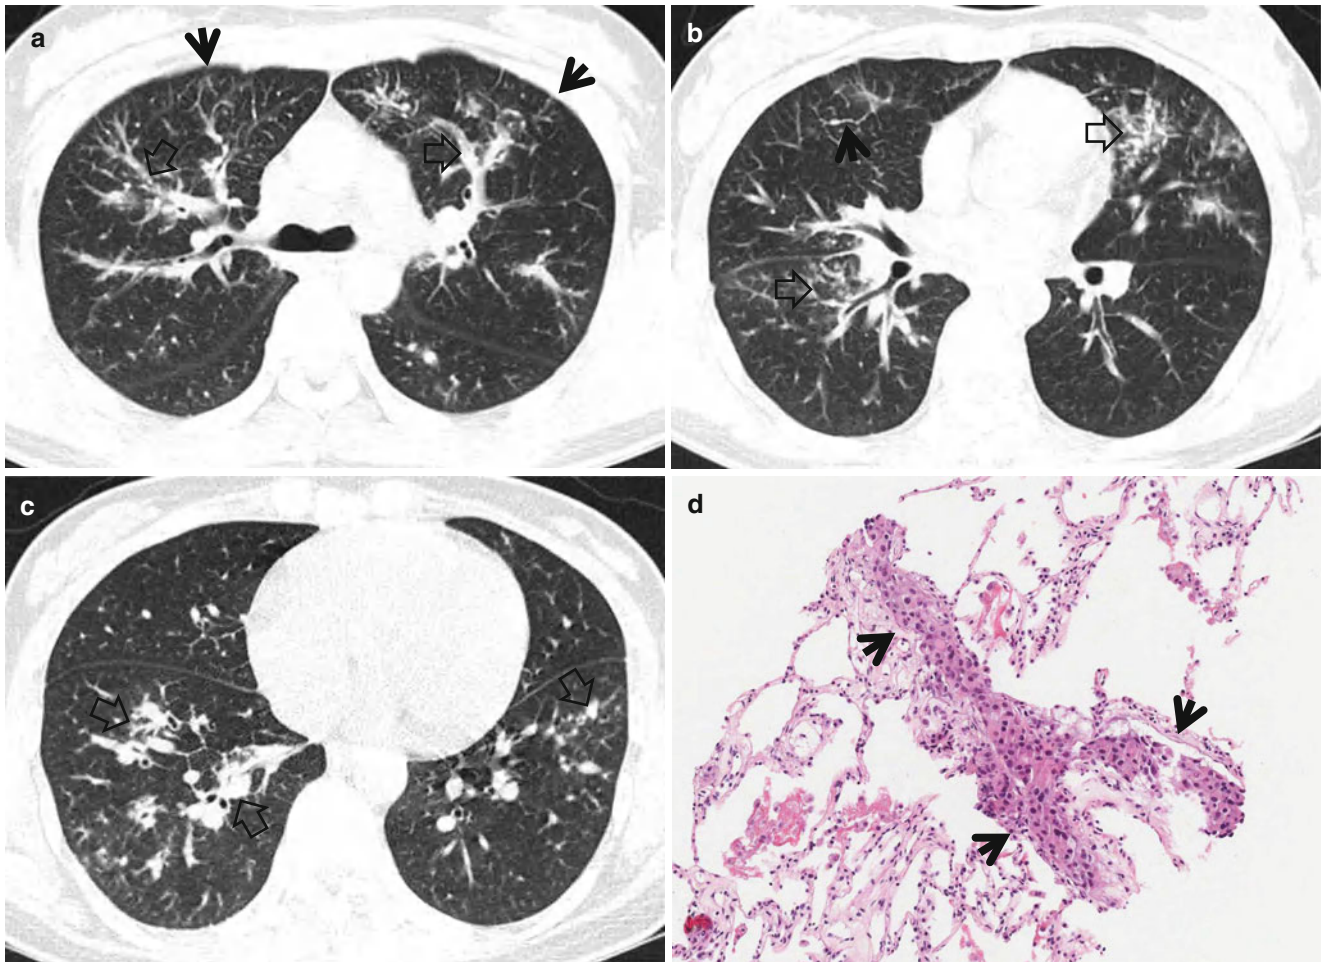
Pulmonary lymphangitic carcinomatosis in a 35-year-old woman with poorly differentiated tubular adenocarcinoma of the stomach. (a–c) Lung window images of thin-section (2.5-mm section thickness) CT scans obtained at levels of right upper (a) and middle (b) lobar bronchi and basal segmental bronchi (c), respectively, show smooth and nodular (arrows)
